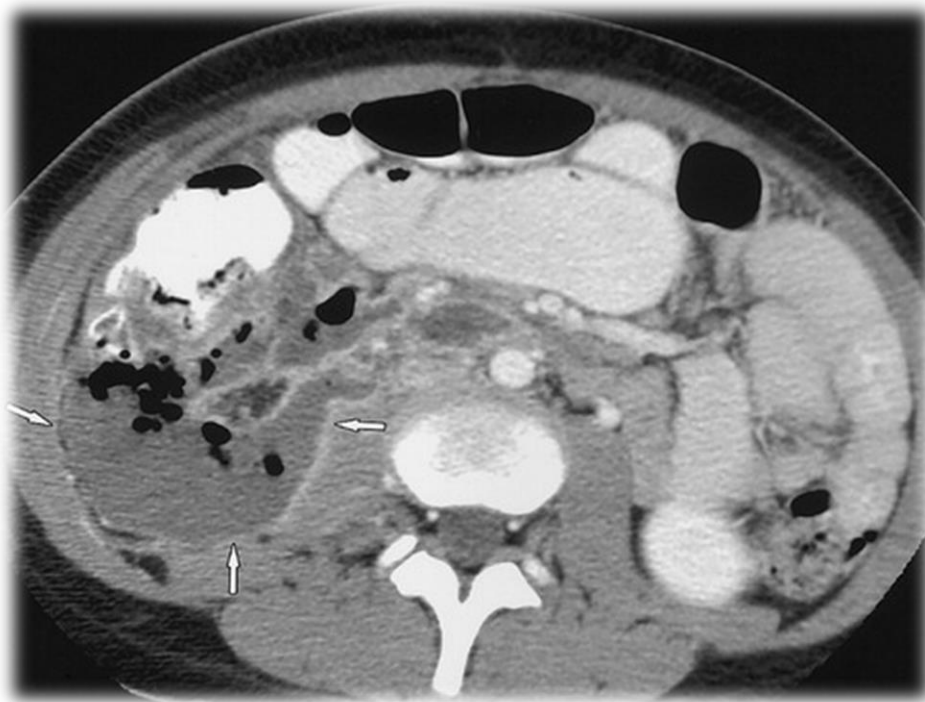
CT guided drainage of an abscess in a 13-year-old female patient after appendectomy. At US, the abscess could not be differentiated from the adjacent bowel. Axial CT image shows a large abscess (arrows) that has a thick enhancing wall and contains air. (21).
